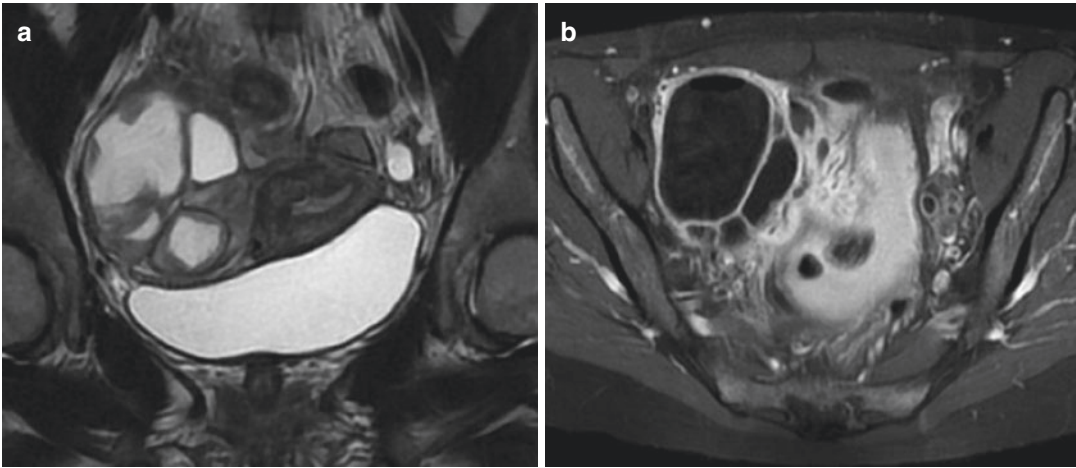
Right tubo-ovarian abscess in a 18 year-old girl with Crohn disease. (a) MR imaging: Coronal T2-Weighted sequence. Tubo-ovarian abscess in contact
